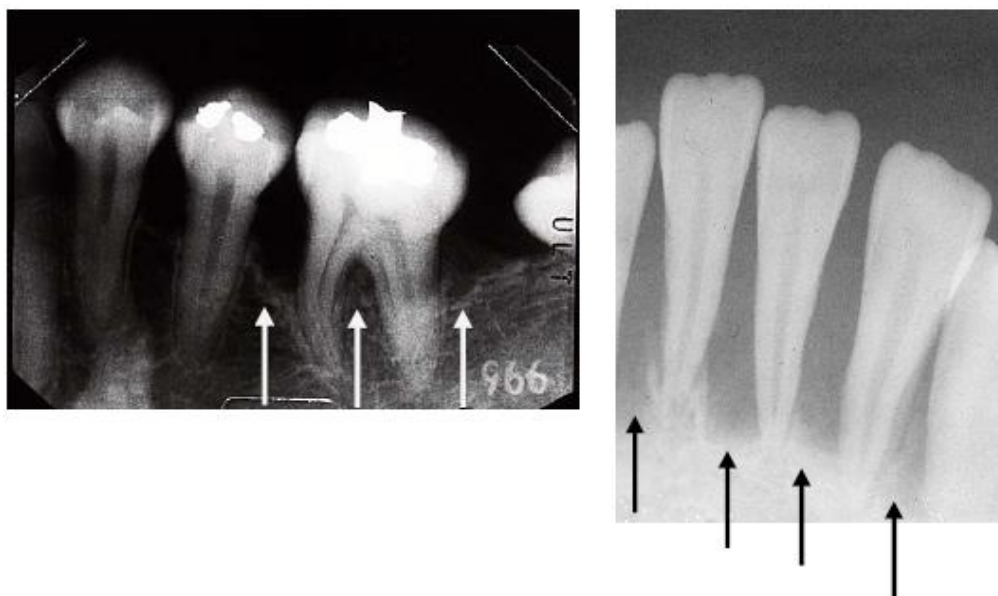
Radiographic features of localized juvenile periodontitis. White and black arrows indicate the resorption of the supportive bone in mandibular first molar and incisors, respectively.
